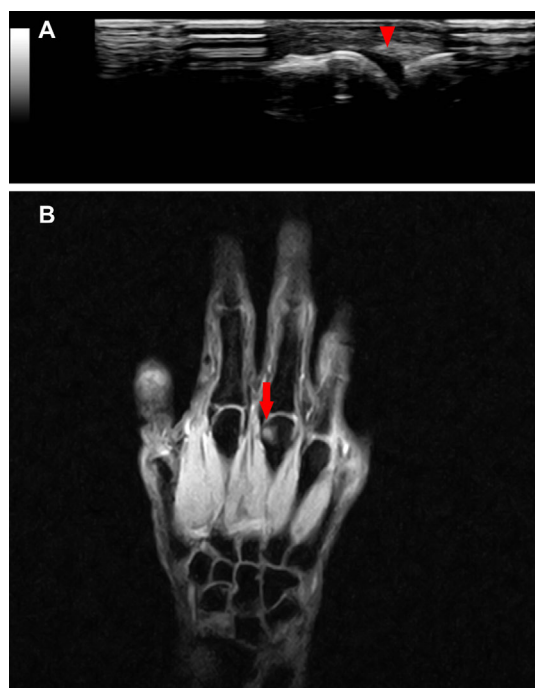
Imaging findings of the hand on Day 1,102. (A) Ultrasound of the right metacarpophalangeal (MP) joints showing synovial thickening (arrowhead), but no joint effusion or power Doppler signals. (B) T2*-weighted magnetic resonance imaging (MRI) of the right hand, indicating bone erosion at the distal end of the third metacarpal bone (arrow).
